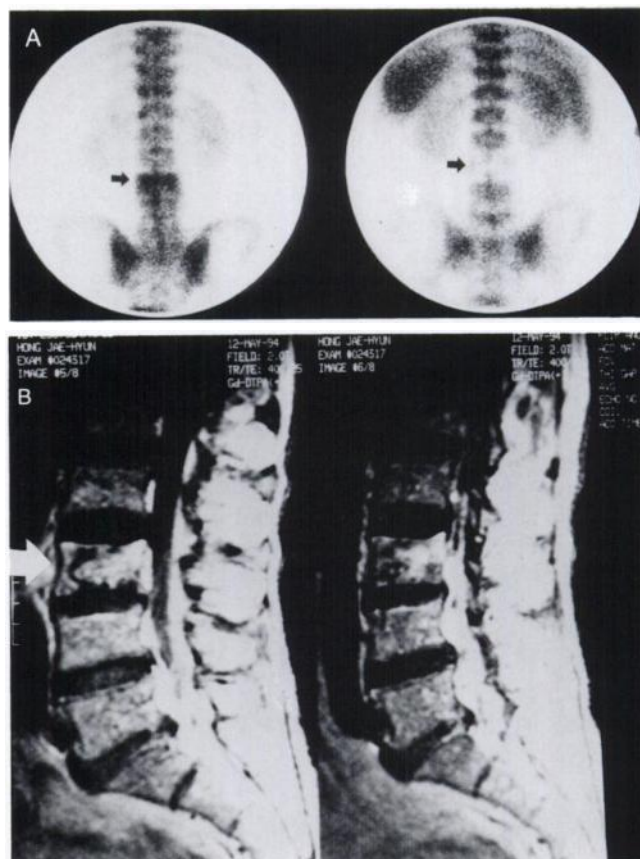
(A) Bone scan of a breast cancer patient shows a lesion in the third lumbar spine (arrow, left image). AGA scan clearly shows a focal marrow defect concordant with the bone scan lesion site (arrow, right image). (B) Metastatic nature of the lesion is confirmed by MRI (arrow).
